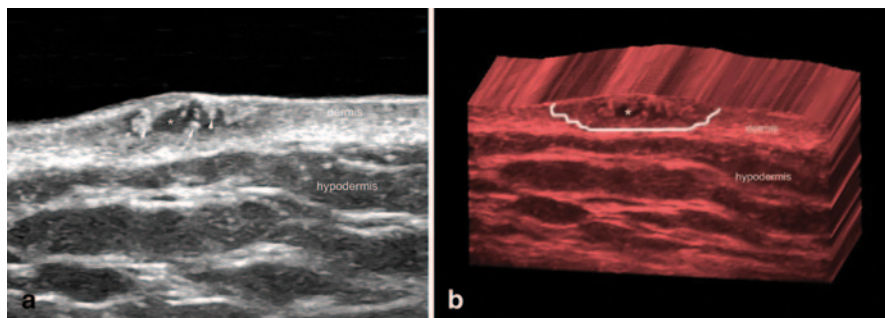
Basal cell carcinoma of the skin (*transverse views, posterior aspect of the left shoulder*). a Ultrasound (*gray scale*) and b 3D reconstruction show hypoechoic dermal lesion (*, *outlined*) with irregular borders and hyperechoic spots (*arrows*)
